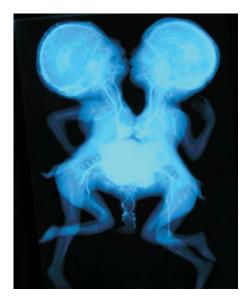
Contrast radiograph of conjoined twins at 20 weeks' gestation indicates sites of vascular connection.
